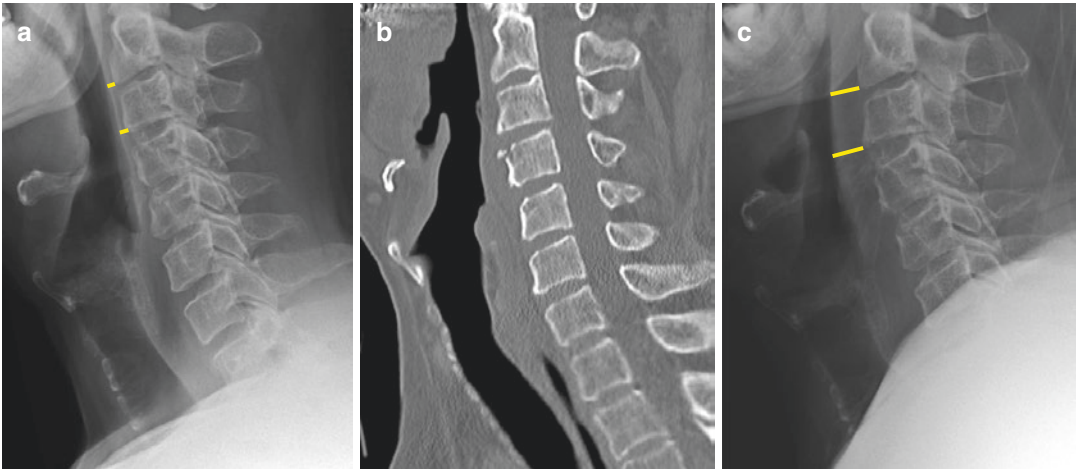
Prevertebral soft tissue space (PVSTS). Pre-injury normal radiographic measurement of PVSTS (a), followed by a fracture of C4 as shown on sagittal MDCT (b), resulting in widened PVSTS radiographic measurements (c)
